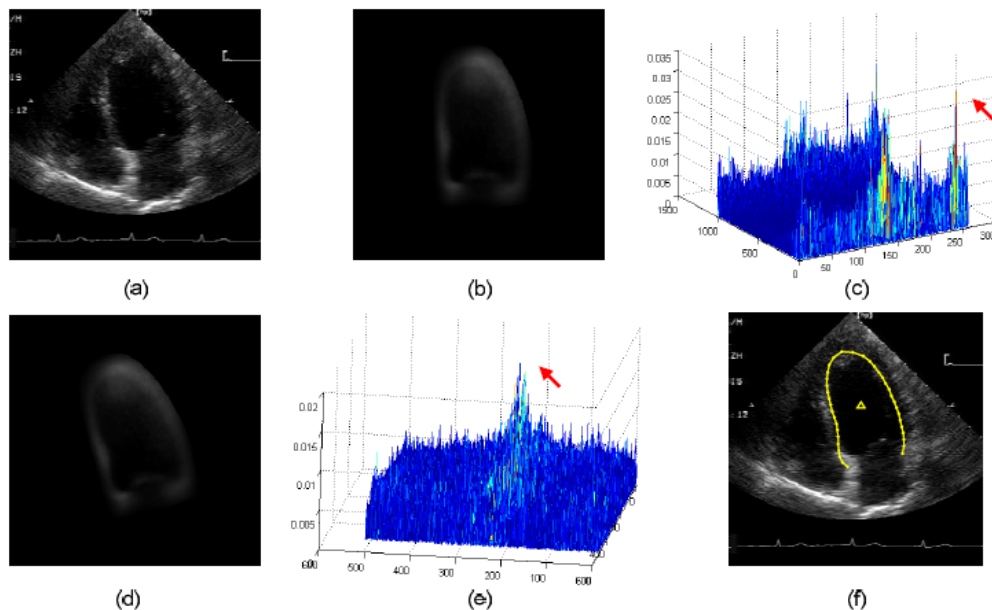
(a) 4 chamber view echocardiogram (ED phase). (b) Template image (c). The peak matrix after matching a and b; the location of the highest peak (indicated by the arrow) indicates the orientation and scaling factor. (d) Based on the scale and orientation detected in (c), the template is rotated and scaled to match the search image (e). By matching (a) and (d), the position of the left ventricle is detected (indicated by the arrow). (f) An average contour is placed on the detected location serving as an initialization of a segmentation algorithm [27].
